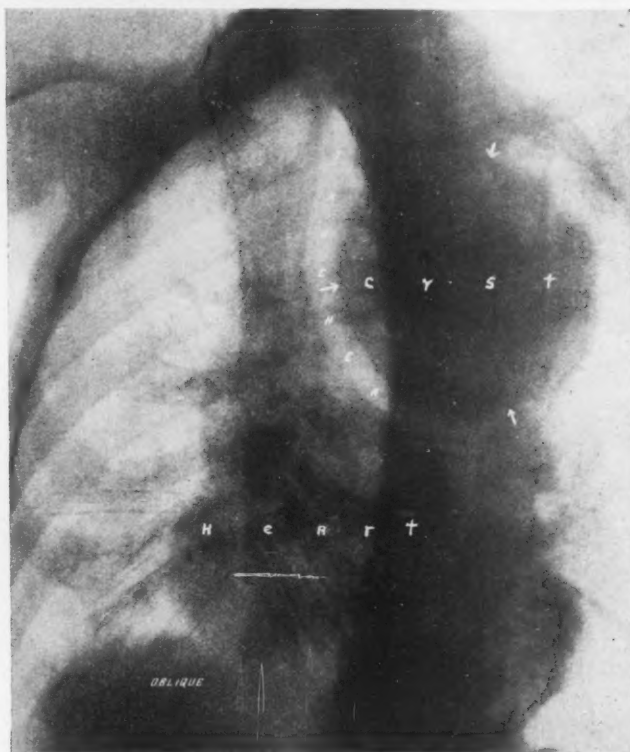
Oblique projection of mediastinal cyst. Note perfect glogular shape. (Radiograph by Dr. L. T. LeWald.)
